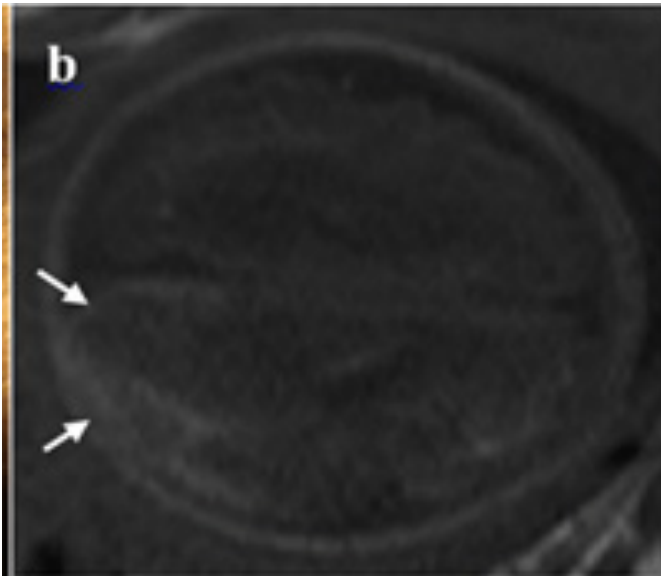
(case 10) axial USG image shows (a), parenchymal hemorrhage in the right frontal lobe (arrowhead) and bilateral intraventricular hyperechogenic clots (arrow) (arrowhead), axial T1 weighted (b) and coronal HASTE (c) images show subdural hemorrhage extending into the posterior of the interhemispheric fissure. (case 6), T2-weighted (d), T1-weight (e) MR and USG (f) images show extensive bleeding (\*) in the cortex and white matter in the left occipital lobe, (g) sagittal USG image shows porencephalic cyst (arrow) in the left occipital lobe.
